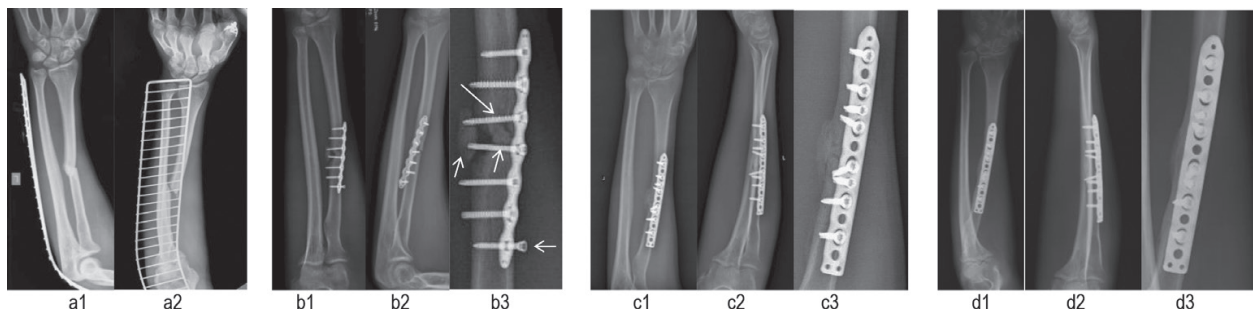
Disturbed healing due to an inadequate stabilization of the comminuted fracture of the left radius shaft in 26-years-old male. The fracture (a1 and a2) was primarily stabilized with the interlocking plate (b1 and b2), but lack of the contact between one of its intermediate fragments precluded the healing. Moreover, mechanical stability was not obtained, as both proximal and distal fragments were stabilized practically with two screws only. The third and the fourth screws situated in-between the fracture gap, were mechanically inefficient and foreclosing the healing; the seventh' was not screwed in at all (b3). Five months later, due to the lack of the progress of the healing (b), the fracture was revised, the fibrous scar was removed and marrow cavity was refreshed, bone fragments were reduced anatomically and stabilized with interlocking plate using four screws for each main fragment. Uneventful healing was observed on X-rays made on the 7th (c) and 12th (d) months after reoperation. Progressive healing (c3) and satisfactory remodeling (d3) were being observed.
